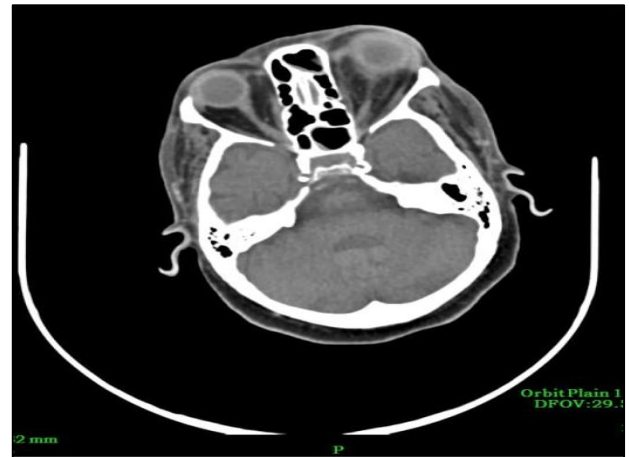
CT-ORBIT with PNS-Proptosis of left eye with subcutaneous oedema, fat stranding, bulky extra ocular muscles s/o left eye orbital cellulitis with panophthalmitis.
